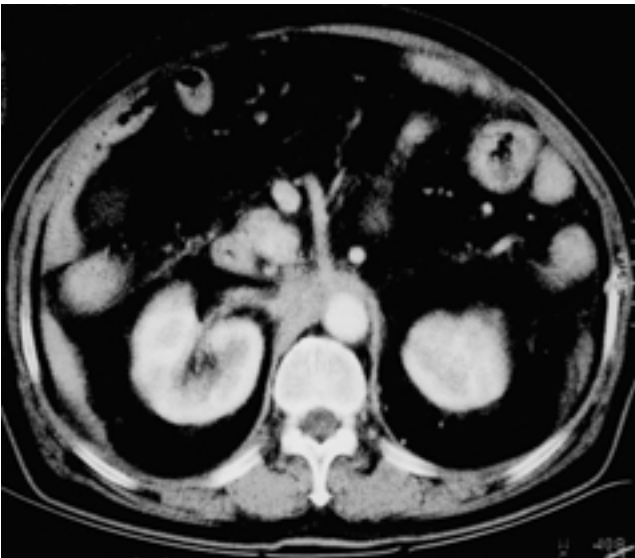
Abdominal CT scan shows metastatic retroperitoneal lymphadenopathy at IVC region without opacification of the IVC.
